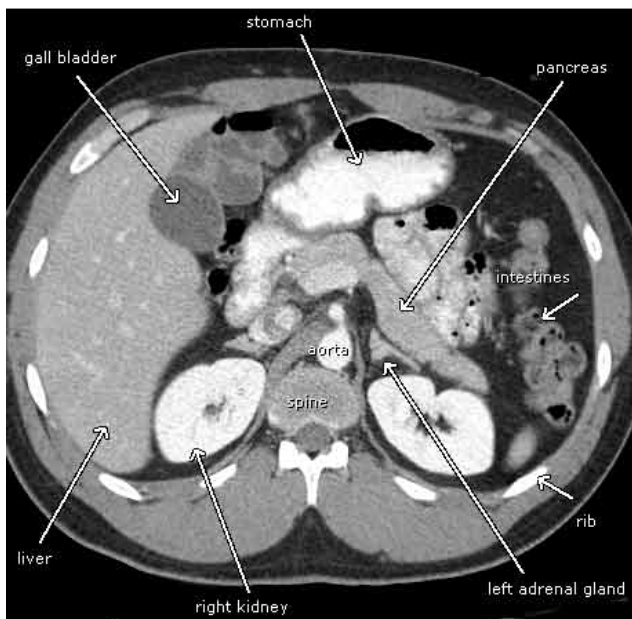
CT slice through the mid-abdomen showing multiple normal-appearing organs
